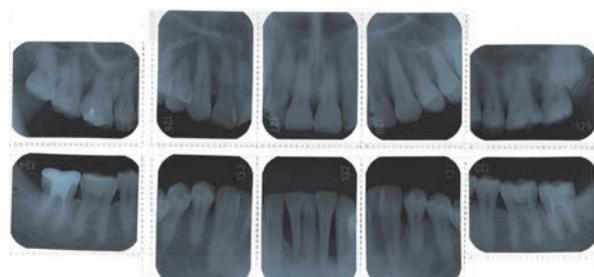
X-ray graph on March 2017
